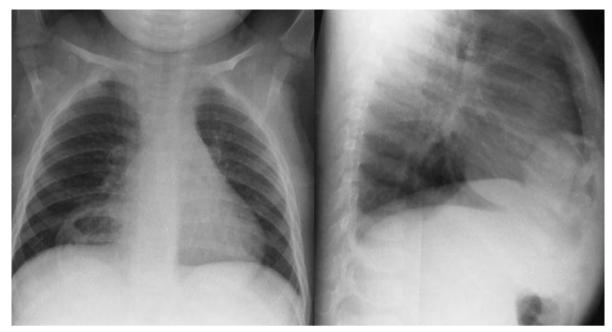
Anterior (Morgagni) diaphragmatic hernia. Anteroposterior chest radiograph showing a rounded shadow at the right heart border (*left*), which on the lateral view appears multiloculated. This shadow represents loops of bowel entering the chest through a defect in the anterior foramen of Morgagni, and surgery is recommended in order to avoid the risk of bowel strangulation.
